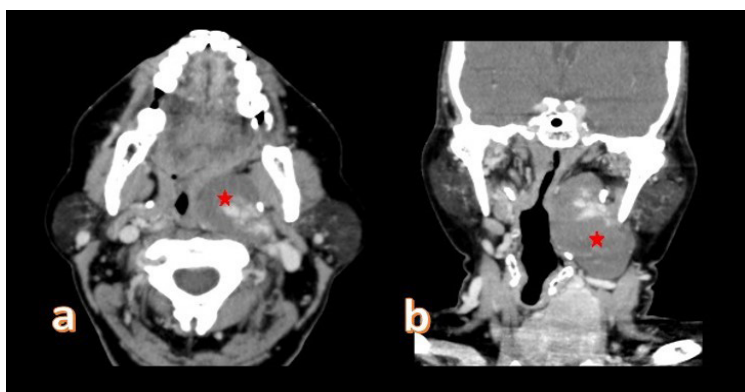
Contrast enhanced CT images in (a) axial (b) coronal plane; showed a well defined heterogeneously enhancing left post styloid parapharyngeal mass, obliterating and displacing parapharyngeal fat space, anteriorly. Evidence of medialization of left lateral pharyngeal wall, causing narrowing oropharyngeal lumen. Enlarged left thyroid lobe noted with clear demarcation between the mass
